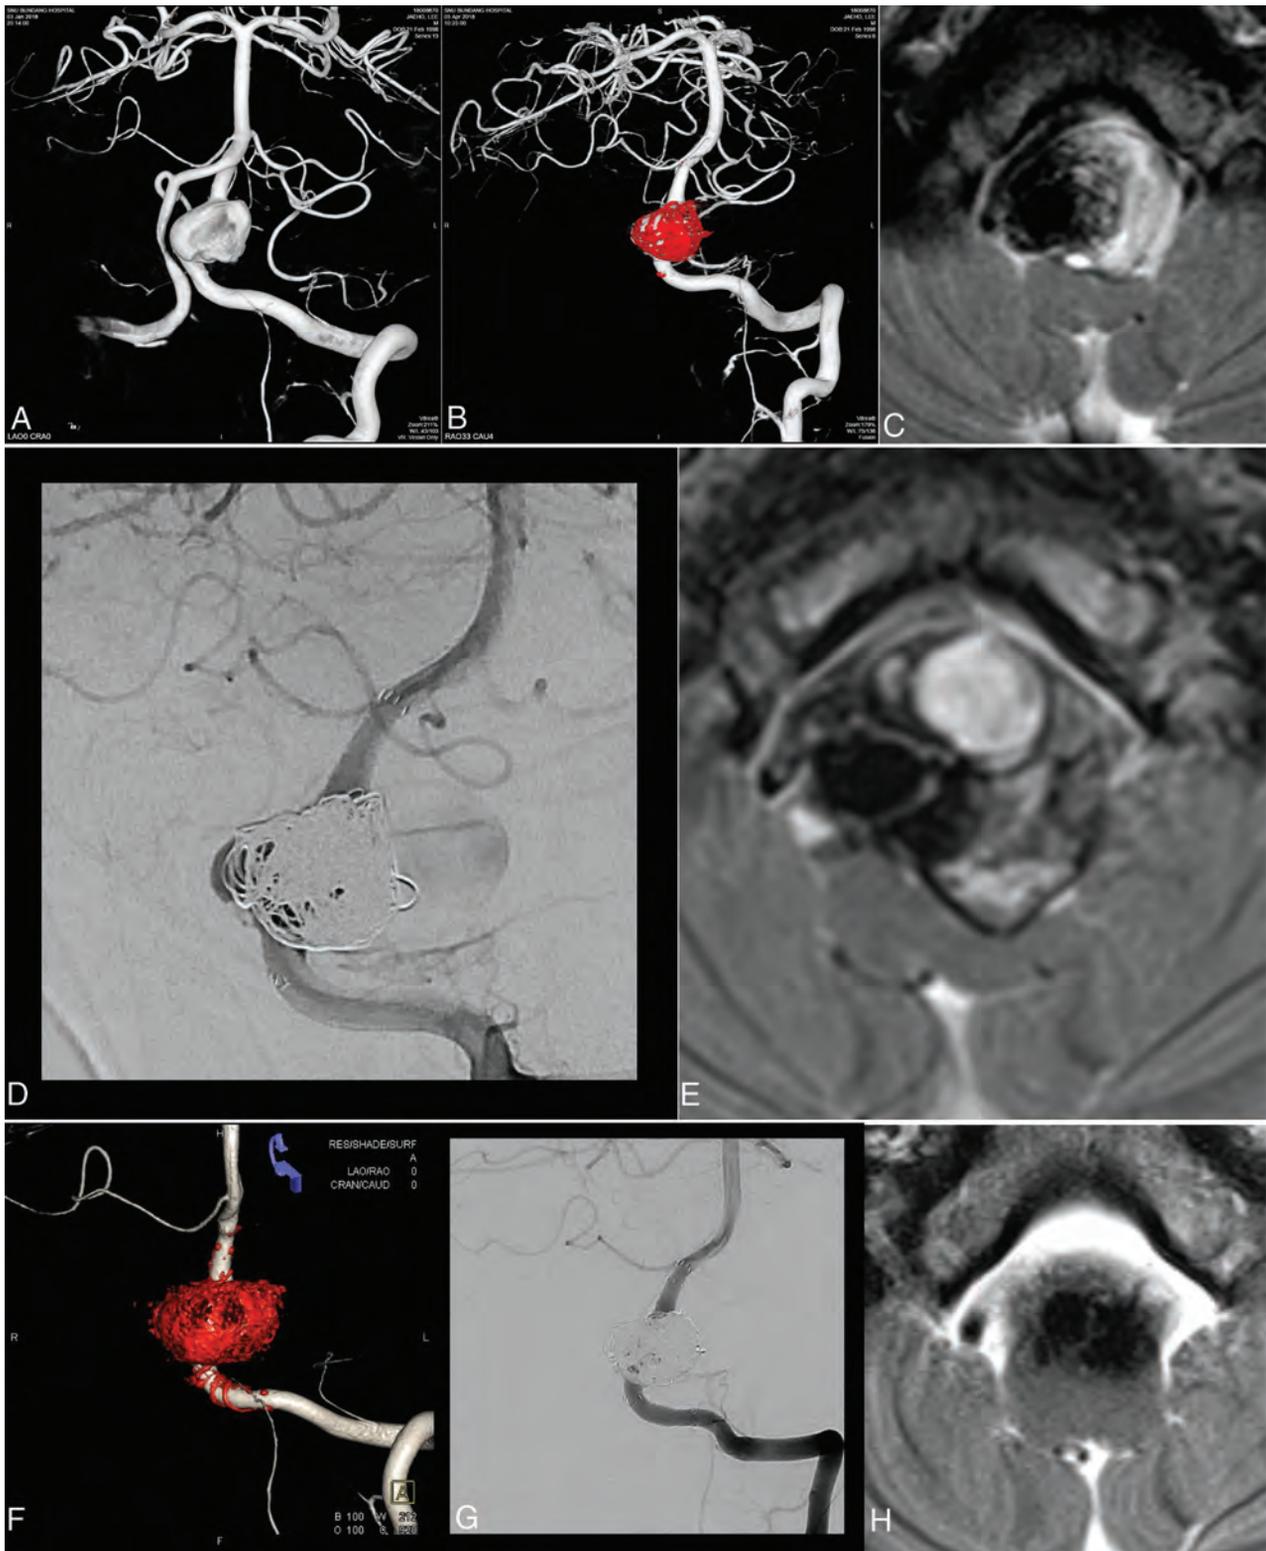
Treatment of large vertebral artery dissecting aneurysm with brain stem compression in a 20-year-old man. *A*, 3D rotational angiography shows a large dissecting aneurysm on the fourth segment of the right vertebral artery. *B*, Stent-assisted coil embolization was performed. *C*, T2 axial MR image on postoperative day 12 shows coil meshes with extended thrombus in the aneurysm sac. *D*, Angiography after 3 months shows a jet flow into aneurysm sac. *E*, T2 axial MR image shows enlargement of aneurysm diameter with aggravation of brain stem compression. *F*, FD was performed using the FRED. *G*, Angiography 5 months after FD shows complete regression of jet inflow. *H*, T2 axial MR imaging shows a markedly decreased aneurysm sac diameter with diminished brain stem compression.
